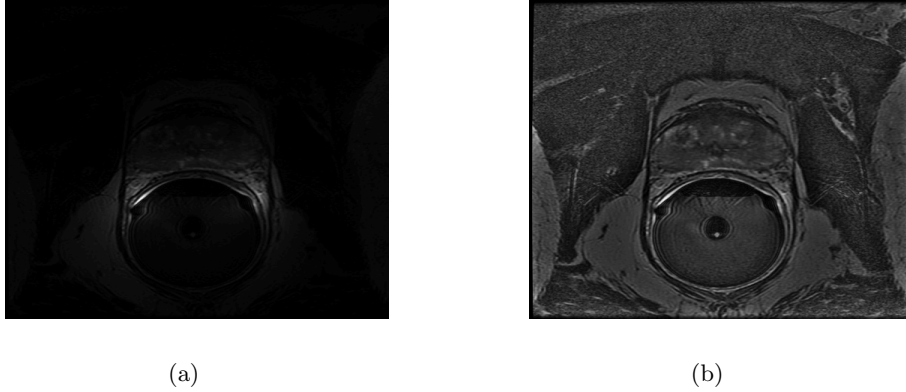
(a) shows a 3 Tesla, T2-w MR image of the prostate. It can be seen that the strong bias field near the center of the image makes the rest of the image too dark to see. (b) shows the same image after preprocessing. The prostate can be seen quite visibly in the center of the image.
